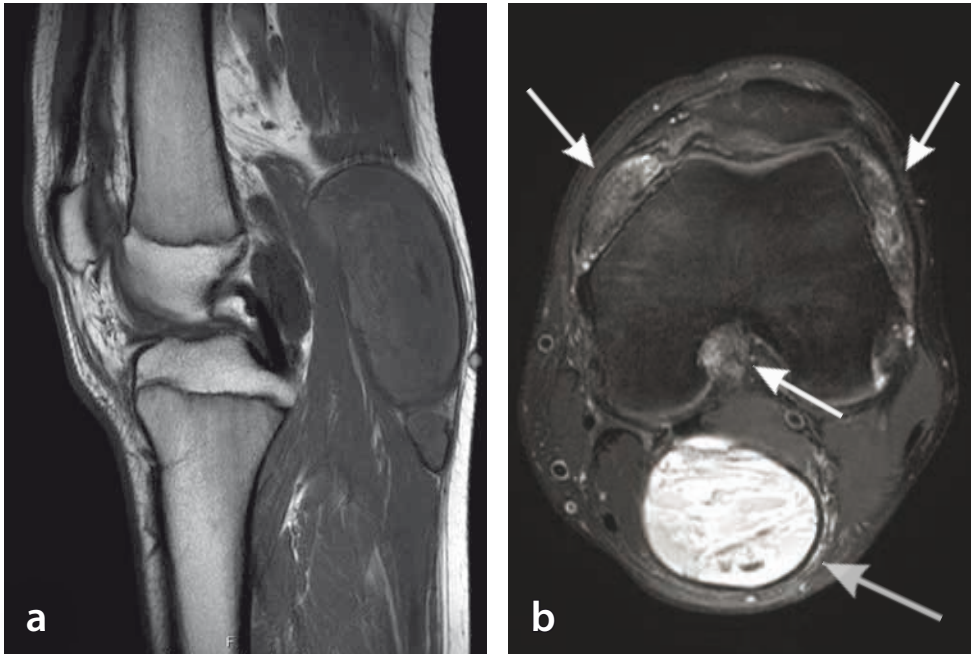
Diffuse type TGCT: MRI of a 16-year-old boy with TGCT in his left knee. a. Sagittal T1-weighted turbo spin echo (TSE) image shows extensive intra- and extra-articular villous proliferation of synovium. Posterior is a large Baker's cyst. b. Transversal T2-weighted TSE image with heterogeneous low to intermediate signal of the TGCT anterior and posterior (white arrows). Baker's cyst is shown posteriorly (bigger grey arrow).
